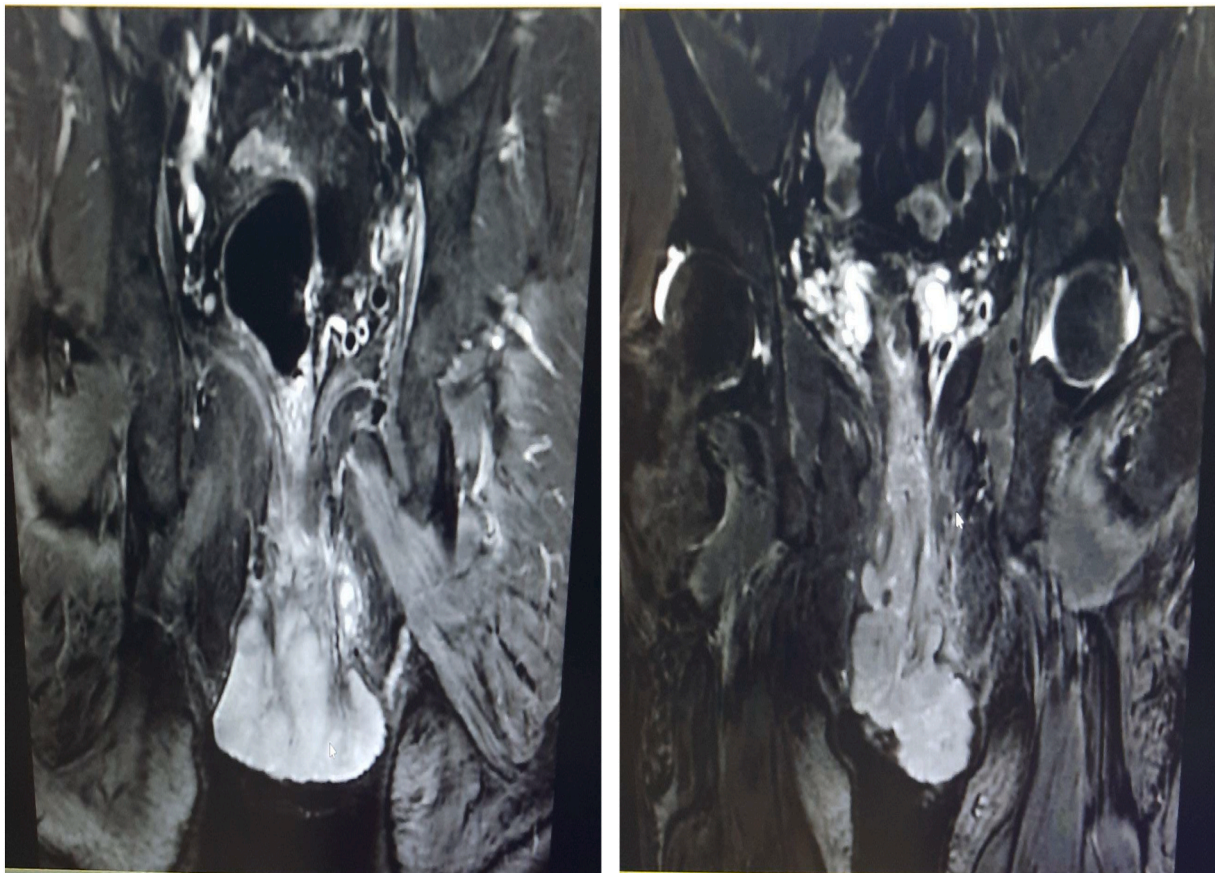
MRI pelvis showed a large exophytic verrucous lesion on the anal verge.
